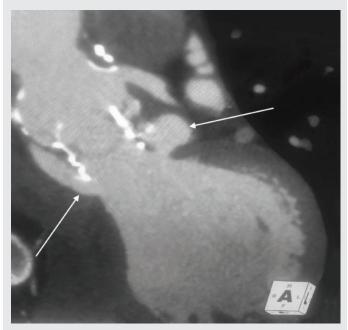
Cardiac computed tomography revealing two pseudoaneurysms laterally extending from the left ventricular outflow tract bilaterally.
